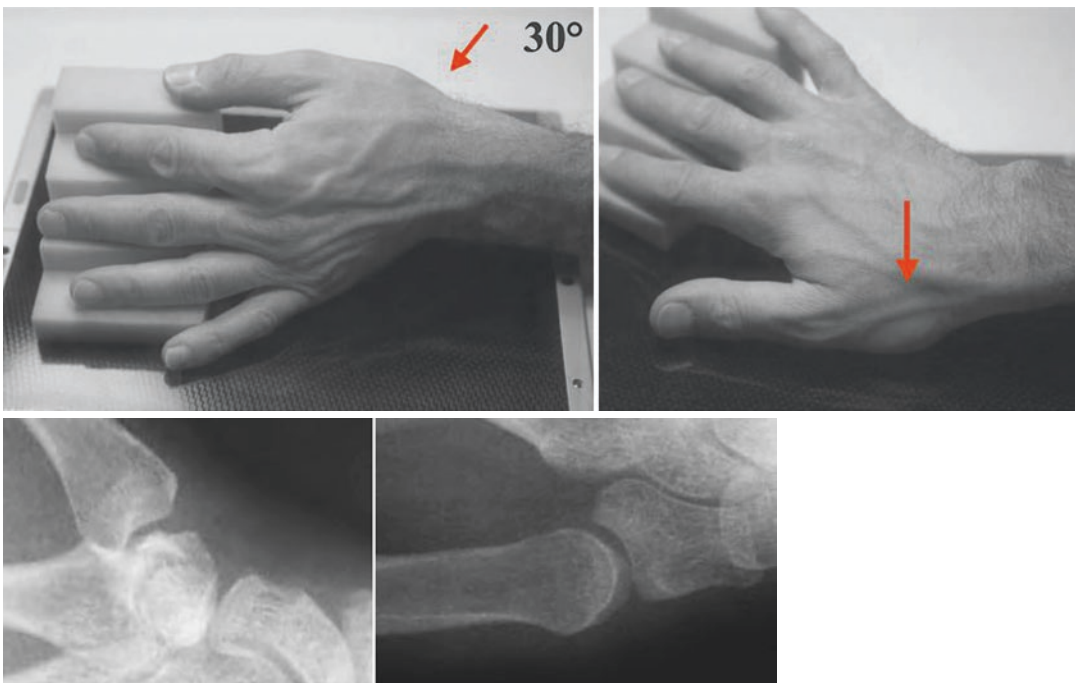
Kapandji incidences for basal joint centered plain X-rays
